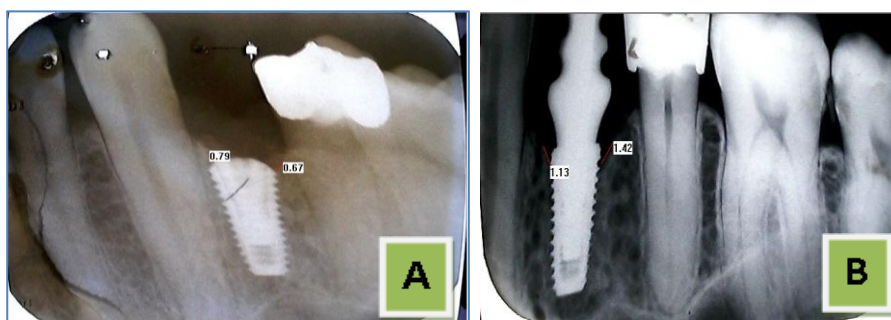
Periapical view show (A: Implant at the base line. B: after 4 months).
